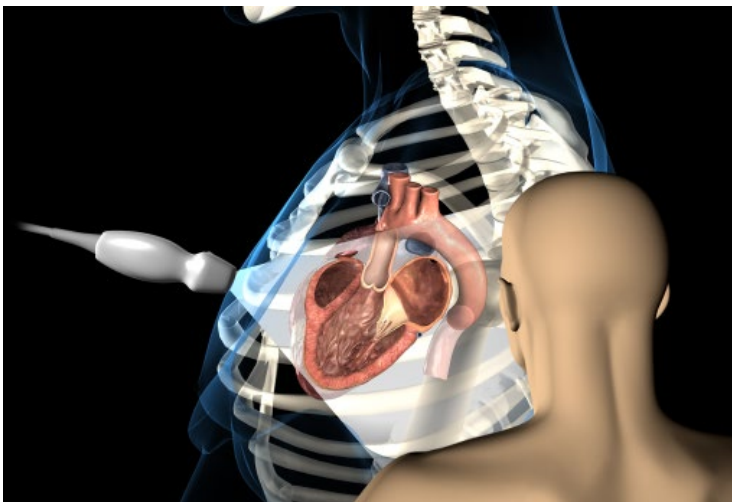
Depiction of the PLAX by viewing the chest from the patient's left side. © CAE Healthcare Inc., 2010; All Rights Reserved. Reproduced with permission from the CAE Healthcare-ICCU e-learning Curriculum on the Use of Bedside Ultrasound. Available at: www.iccuelearning.com.
